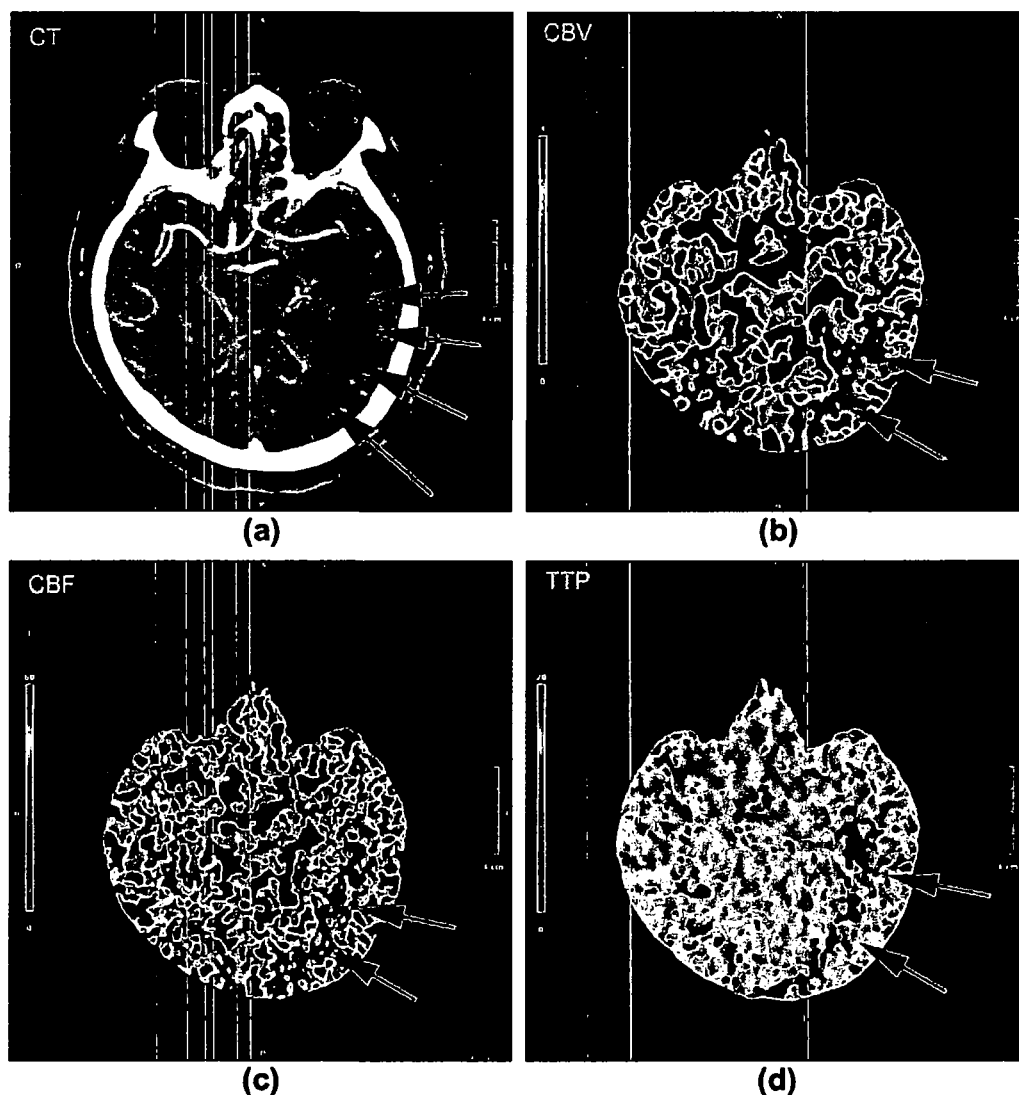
A 57-year-old man with chronic left ICA occlusion and hemispheric CTP deficits. (a) Decreased attenuation in the left hemisphere on the contrast-enhanced CT corresponds to the (b) area of decreased CBV, (c) decreased CBF, and (d) prolonged TTP. There are similar patterns of decreased CBV and CBF in the distal bilateral PCA regions. Prolonged TTP is present in the areas of chronic ischaemia.
